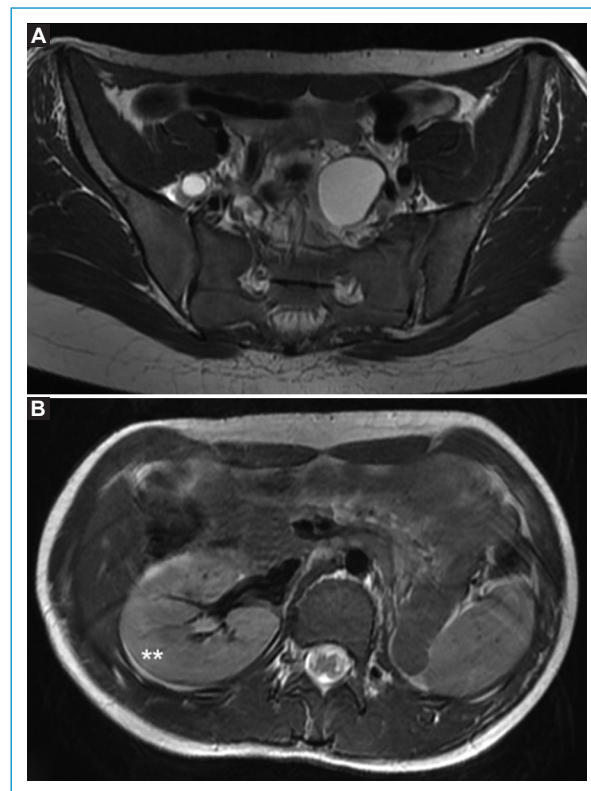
Additional findings. Axial T2-weighted image of the pelvis (A) shows a cystic lesion on the left (*) corresponding to the multicystic dysplastic kidney. A normal right ovary is depicted (arrow). Axial T2-weighted image of the upper abdomen (B) reveals a normal right kidney () and an absent left kidney.
